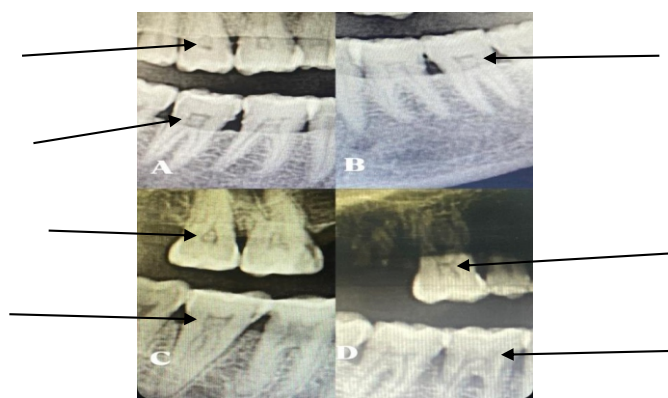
On the Panoramic Radiograph, Pulp Stones were seen Inside the Molars' Pulp Chambers
